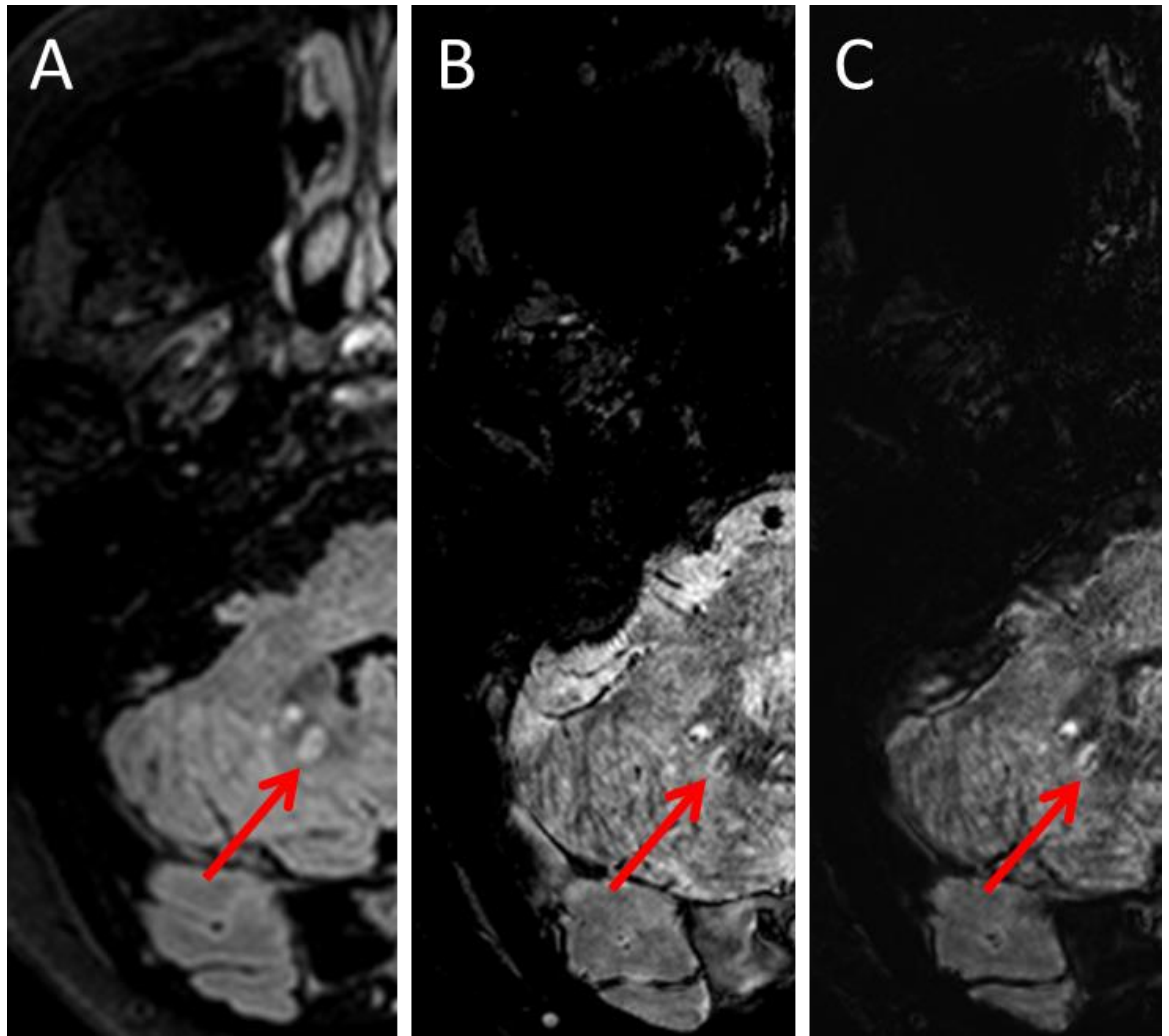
Infratentorial MS lesion in the cerebellum. (A) shows the lesion on FLAIR, (B) is a T2* hEPI image which shows the lesion reasonably well, (C) is a FLAIR-SWI-2 scan which clearly depicts a well demarcated lesion with a central vein.
